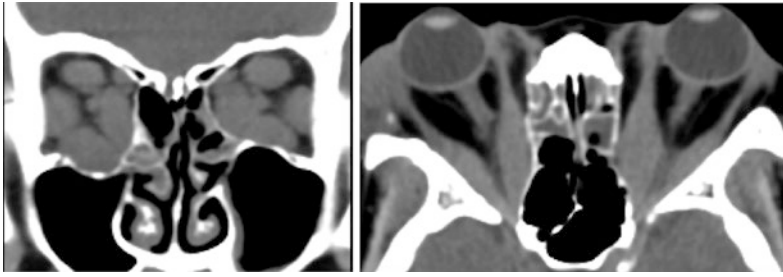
Bilateral thyroid ophthalmopathy in a 40-year-old female. a, b Coronal and axial CT images demonstrate bilateral fusiform enlargement of the extraocular muscles sparing the tendinous insertion
